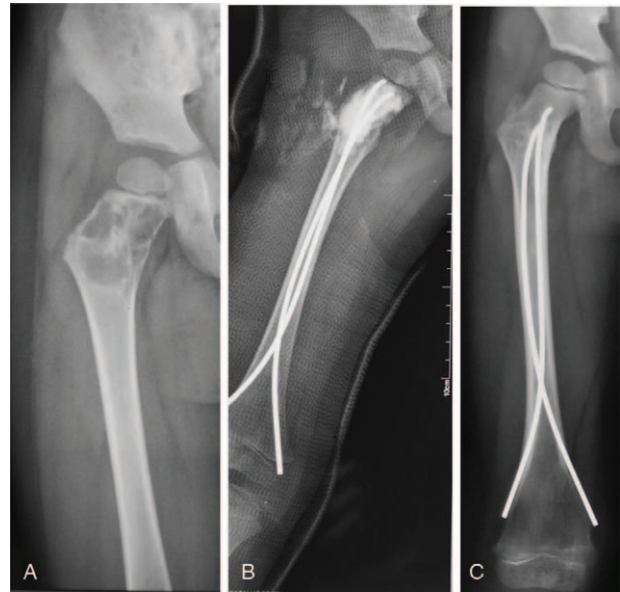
right proximal femoral fracture caused by SBC in a 3-year-old boy is stabilized by Double ESINs A. Preoperative image of right femur B. Postoperative image of right femur treated by double ESINs C. X-ray of the right femur at 24-month follow-up.
